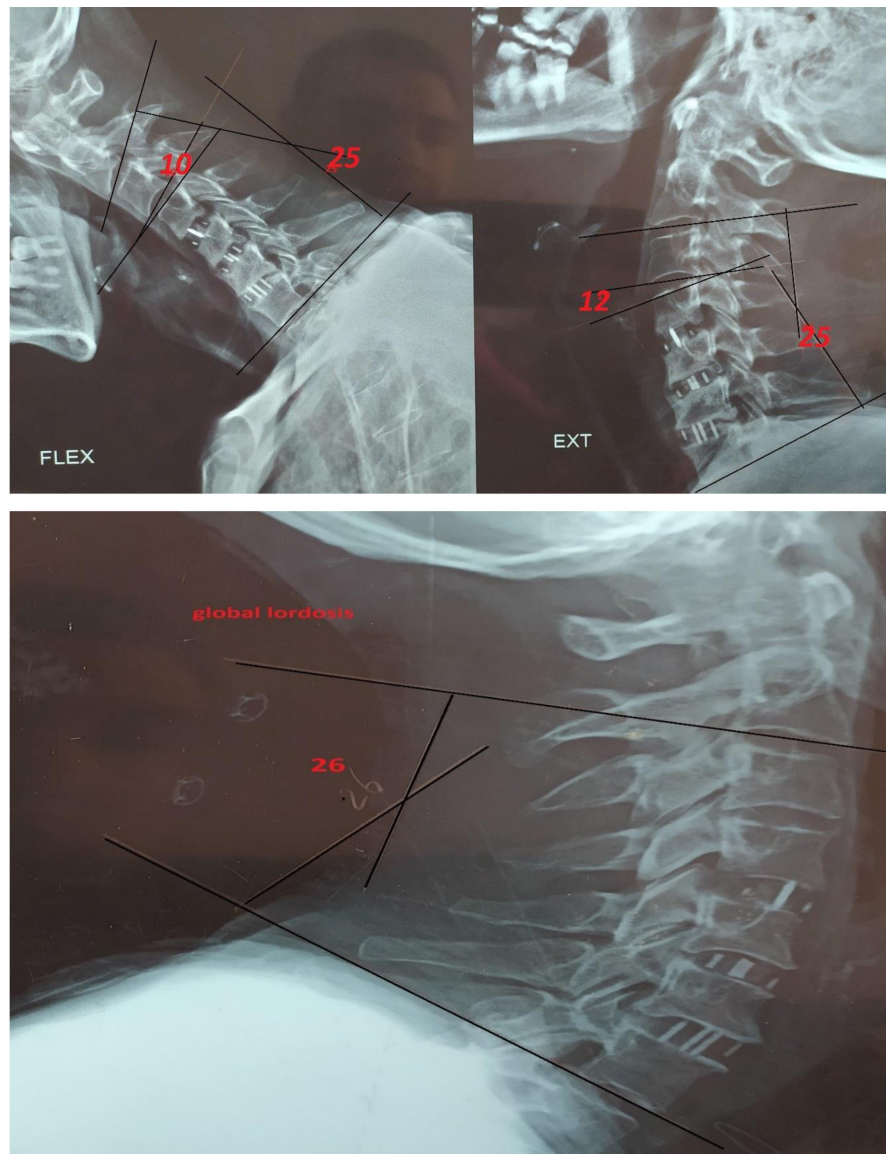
6 months Postoperative X-ray Cervical spine flexion, extension and lateral views show that global lordosis was 26 and global ROM increased to 50 (25 for extension and 25 for flexion). Cranial ROM also increased to 22 (12 for extension and 10 for flexion).
